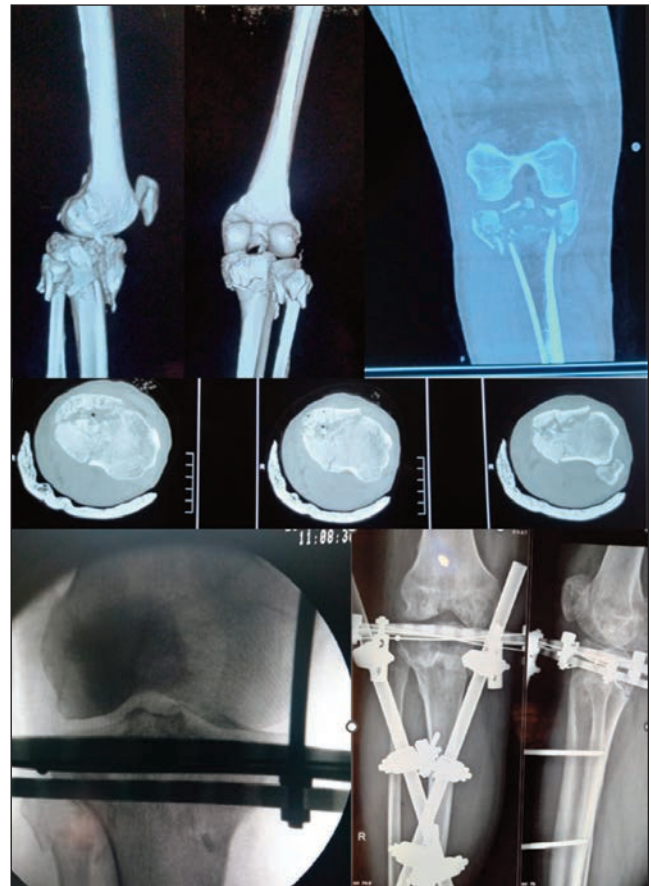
Three-dimensional (3D) computed tomography (CT) scan of a patient with three-column fracture of proximal tibia operated with hybrid external fixator showing union.
